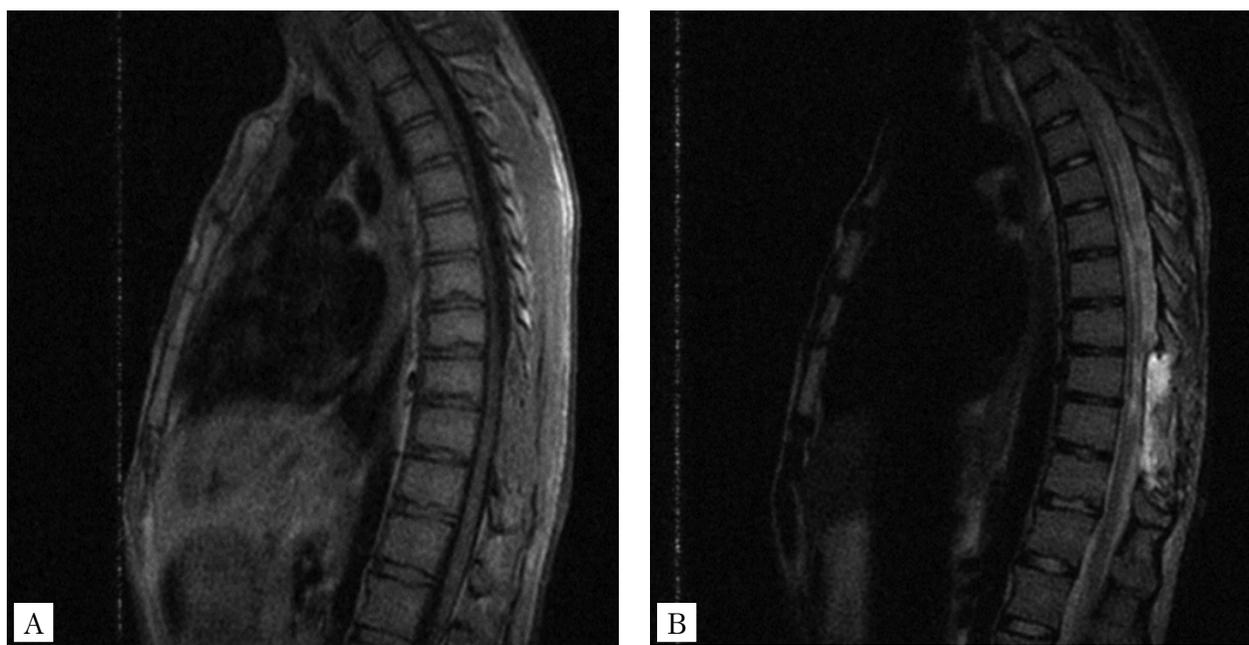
Postsurgical T1-weighted (A) and enhanced T2-weighted (B) MRI images of a spinal cord anaplastic astrocytoma (WHO grade III) on the Th8-Th10 level in a 49-year-old male 3 weeks after subtotal removal. Clinical symptoms without improvement
